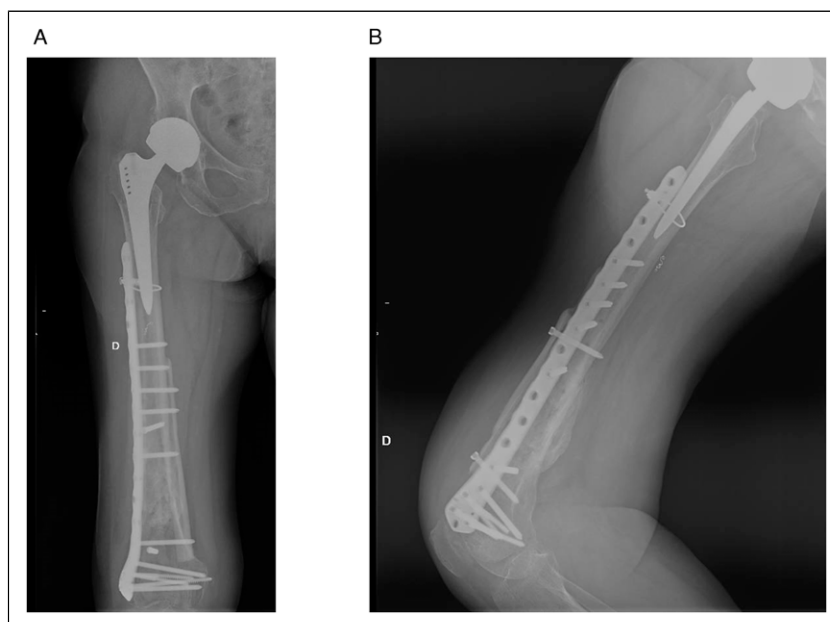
The final construct of case in Figure 3 (A, antero-posterior and B, lateral radiographs). Bone healing occurred at 4 months after surgery.
